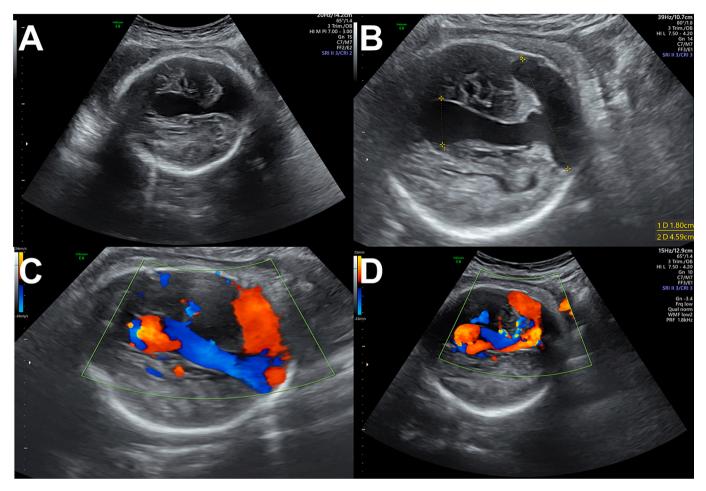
Axial two-dimensional ultrasound image of the affected fetus with vein of Galen arteriovenous malformation at a gestational age of 35 weeks. A: A large thinwalled anechoic area next to the midline of the brain. B: Marked dilatation of the fetal brain vasculature measuring 1.8 cm in the anterior segment and 4.7 cm in the posterior segment. C and D: Color Doppler shows a full blood flow signal in the brain's anechoic area.
